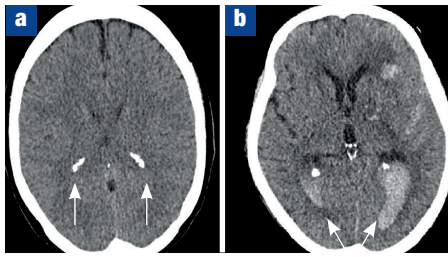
A common pitfall for the unfamiliar eye. a. Normal appearances of calcified choroid plexus. Calcification is hyperdense on computed tomography and can be seen in commonly calcified intracranial structures such as the choroid plexus and pineal gland (arrows). This is a normal physiological finding and should not be mistaken for acute haemorrhage. b. Appearances of an intraventricular haemorrhage, alongside subarachnoid haemorrhage and intracerebral haemorrhage (arrows). Note that the density of calcification from the choroid plexus is much greater than that of acute blood when seen on the same image.
